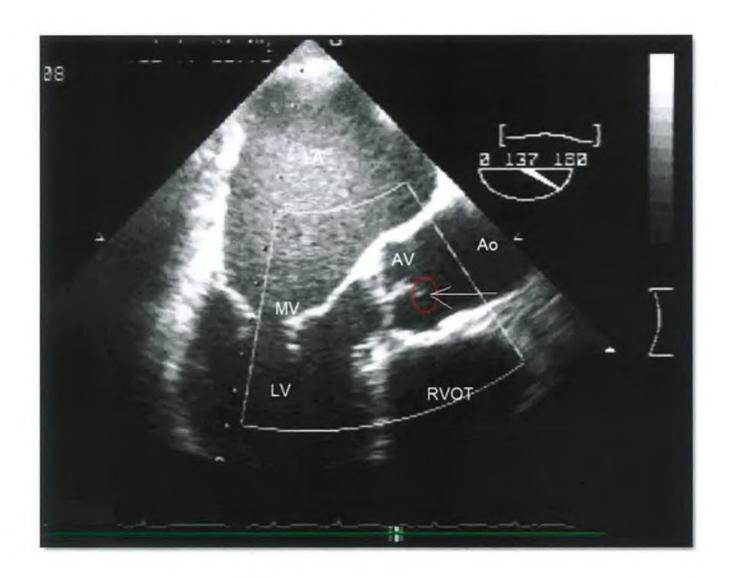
Transoesophageal echocardiographic image aortic valvular strand (red circle) with independent motion to the aortic valve leaflets. LA left atrium, LV left ventricle, AV aortic valve, Ao aorta, RVOT right ventricular outflow tract.
